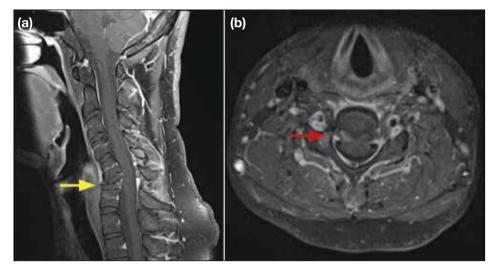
Case 2. Follow-up magnetic resonance imaging after four doses of denosumab. (a) Post-gadolinium sagittal image and (b) axial image show marked shrinkage of the enhancing tumour (yellow arrow) and improvement in spinal stenosis, with only a small residual enhancing area over the right pedicle seen (red arrow).
